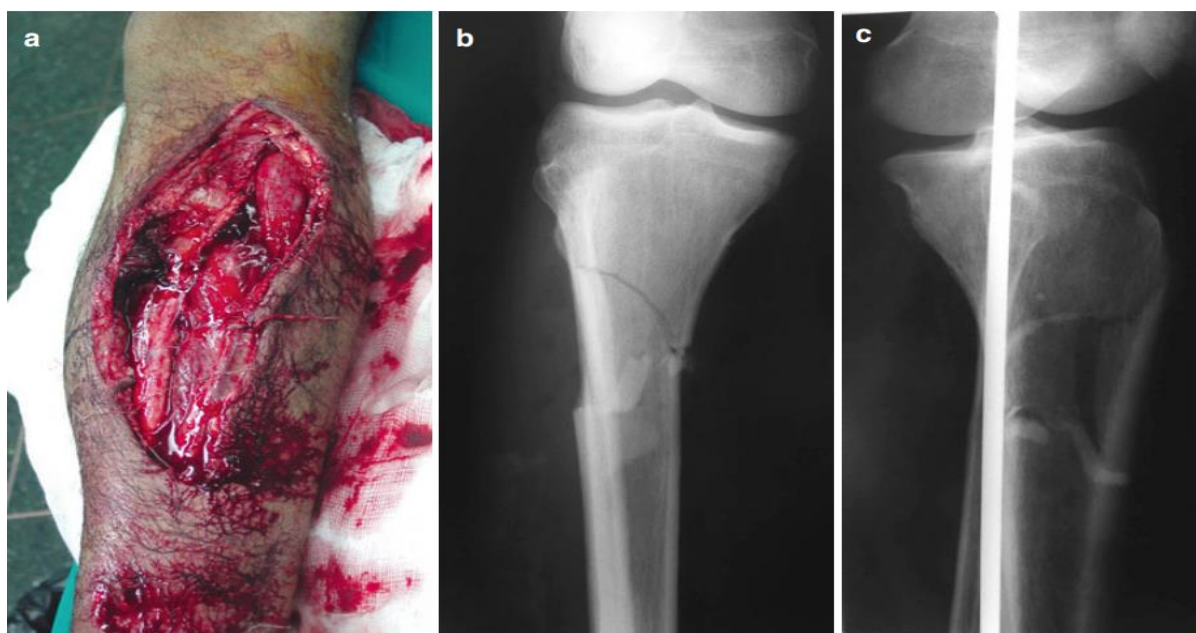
“Open fracture of the proximal tibia. (a) Clinical presentation. (b) Antero-posterior x-ray. (c) Lateral x-ray”
